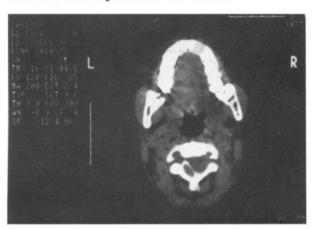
CT-Myelography of the craniovertebral junction. The spinal cord is on the left side while the tumour is on the right.
